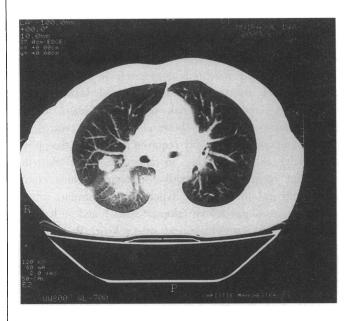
A thoracic CT scan of a heart/lung transplant recipient eight months following transplantation. This demonstrates three nodules, 2 cm in diameter in the right lower lobe. An open lung biopsy confirmed the diagnosis of high grade B cell lymphoma
